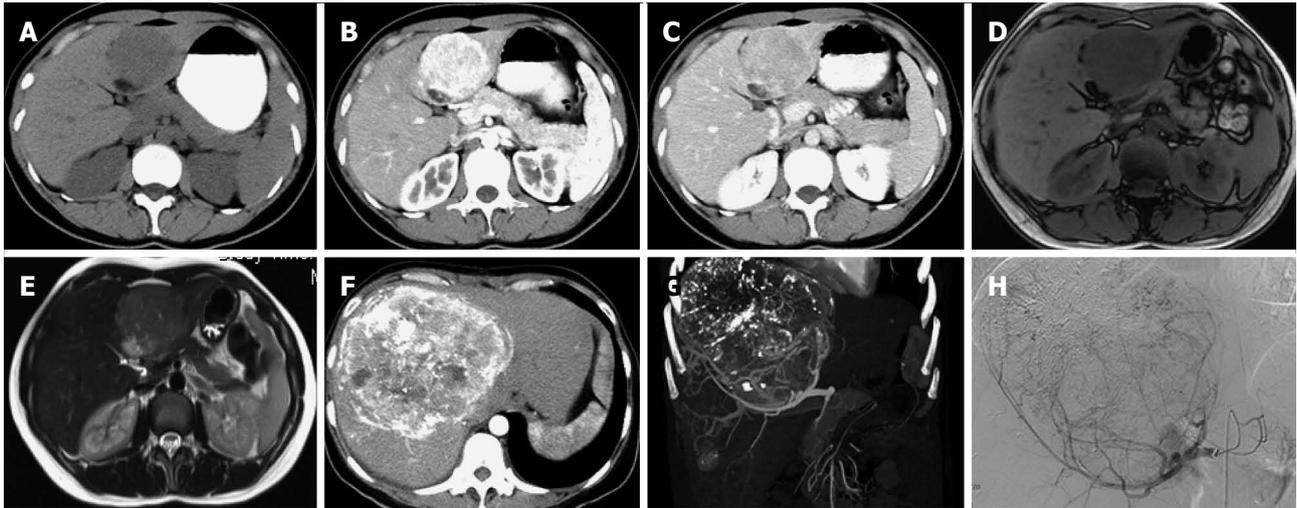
Imaging findings. A: The tumor was hypoechoic on computed tomography (CT); B, C: Enhanced CT showed a tumor (7.0 cm × 9.0 cm) with early-phase hyperattenuation and late-phase hypoattenuation; D, E: Magnetic resonance imaging showed a tumor with hypointensity on T1-weighted, hyperintensity on T2-weighted; F, G: Enhanced CT showed two hepatic masses (13.0 cm × 12.0 cm and 2.3 cm × 1.8 cm) in the right lobe; H: Angiography revealed a circumscribed hypervascular mass.
